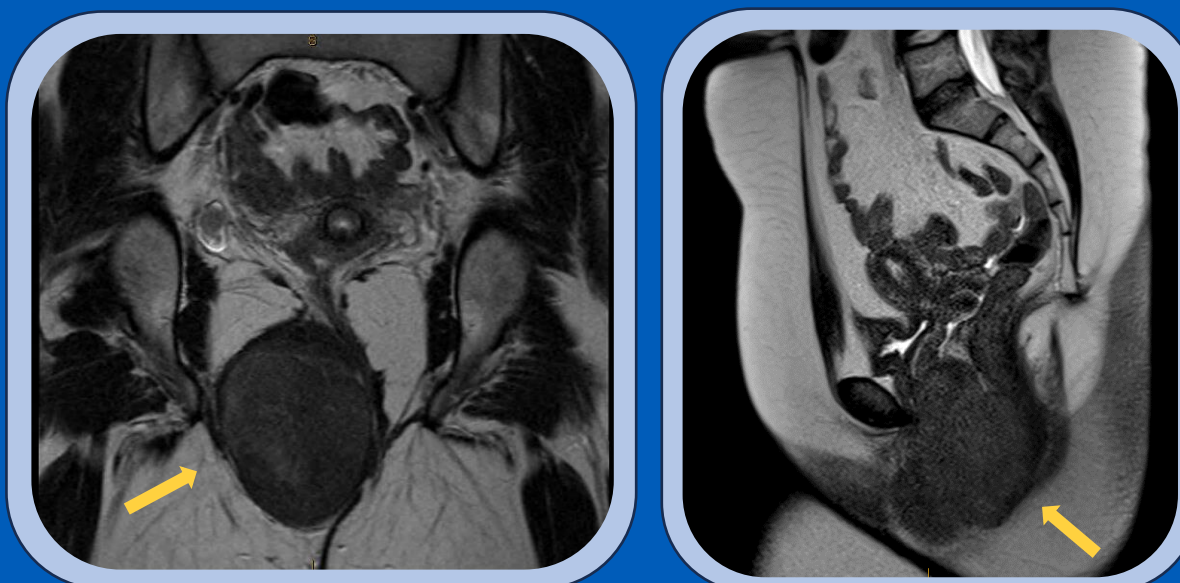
Pelvic MRI revealed lobular right-sided vulvar mass measuring 9.6 x 9.1 x 7.2cm, displacing the rectum to the left without evidence of tumor invasion. MRI features most suggestive of leiomyoma.
